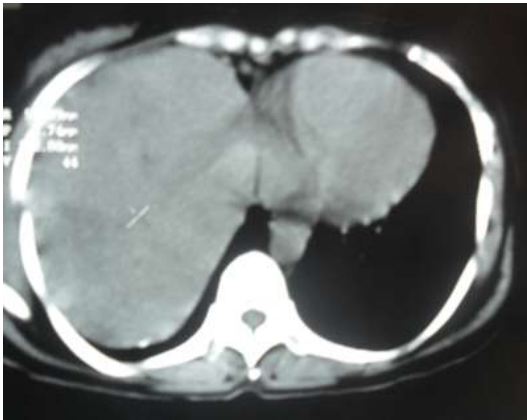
Computed tomography shows mass medially abutting mediastinal structures with doubtful infiltration
